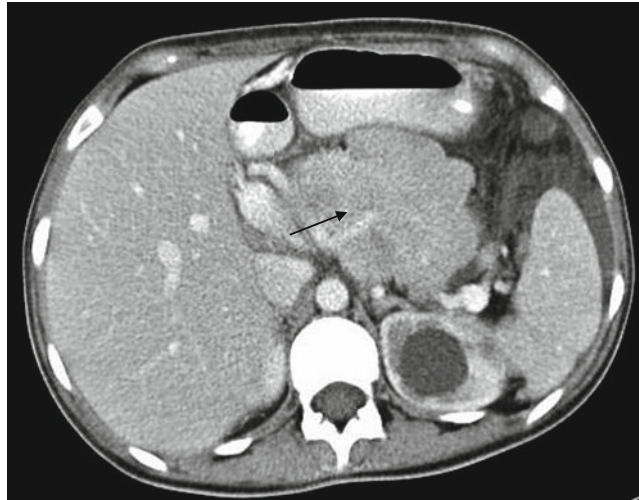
CT of the abdomen showing epigastric neoplastic mass with encasement of major coeliac axis branches (*arrow*)
